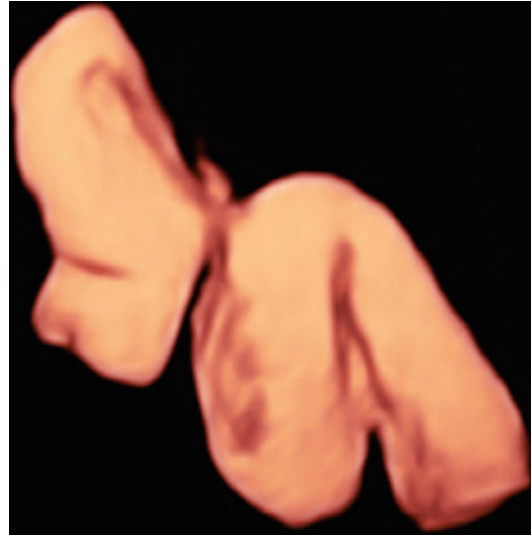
3-D ultrasound inversion rendering image used to identify a hydrosalpinx
